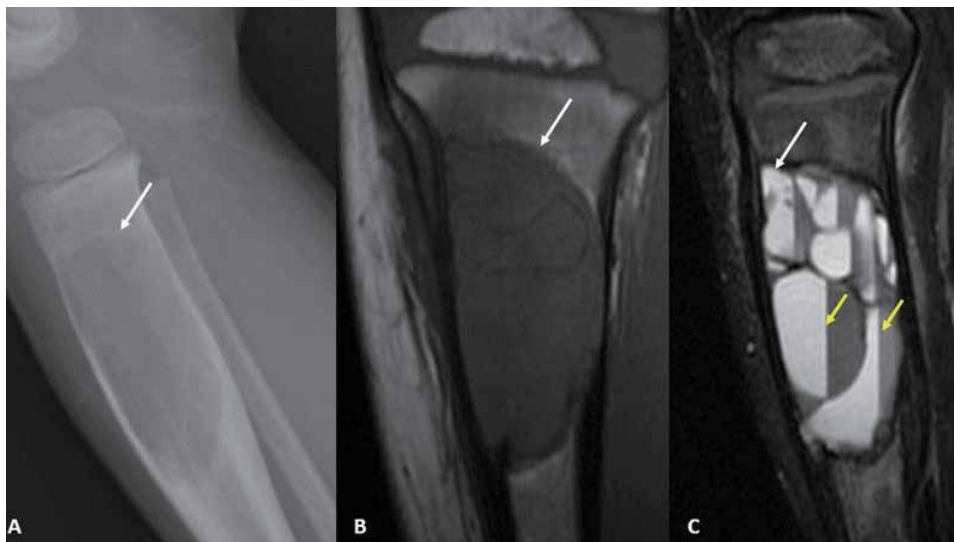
Aneurysmal Bone Cyst: Lateral radiograph of the left tibia (A) shows a well-circumscribed, expansile, lytic lesion (white arrow) involving the proximal tibial metadiaphysis. It demonstrates internal heterogeneity and has a narrow zone of transition. Coronal T1-weighted image (B) reveals the multiloculated appearance of the lesion (white arrow) and a predominantly intermediate T1 signal. No associated soft tissue swelling is noted. Sagittal fat-saturated T2-weighted image (C) shows multiple fluid-fluid levels within the lesion (yellow arrows), a characteristic imaging feature of an aneurysmal bone cyst.
